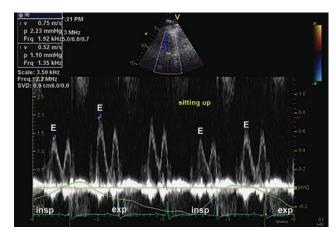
CP: apical four-chamber view with PW Doppler of the mitral inflow in a patient with CP. The study is performed with the patient in the upright position to decrease preload and increase respiratory variation. Marked respiratory variation of mitral inflow E wave is apparent. This maneuver should be performed if CP is suspected but not readily evident in the basal state.
